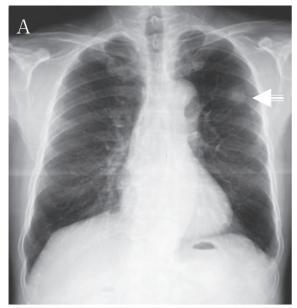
(A) Chest roentgenogram and (B) computed tomogram revealed a mass (arrow) measuring 1.8 cm in diameter in the upper lobe of the left lung.
